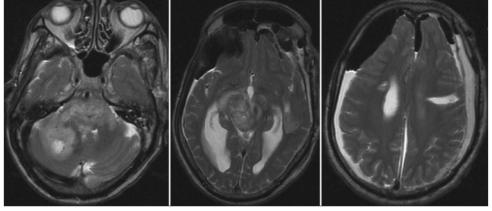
Immediate postoperative MRI showing multiple mixed intensity lesions with edema and pneumocephalus with ventricular compression
